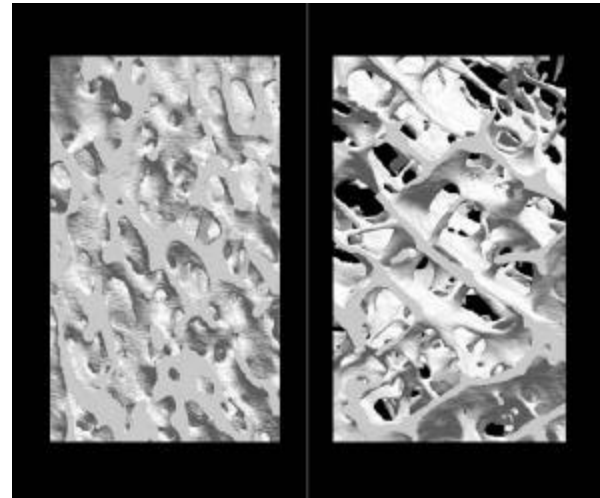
Computer-generated three dimensional images of unaffected bone (left panel) and osteoporotic bone (right panel) from μ CT scans.
